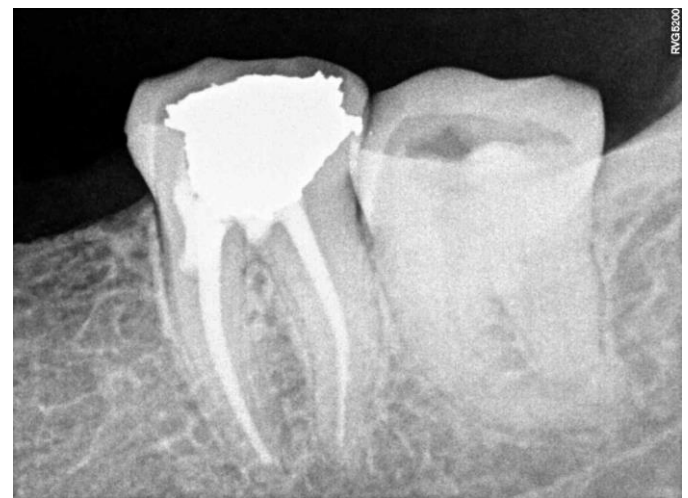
A: Pre-Operative Radiograph
